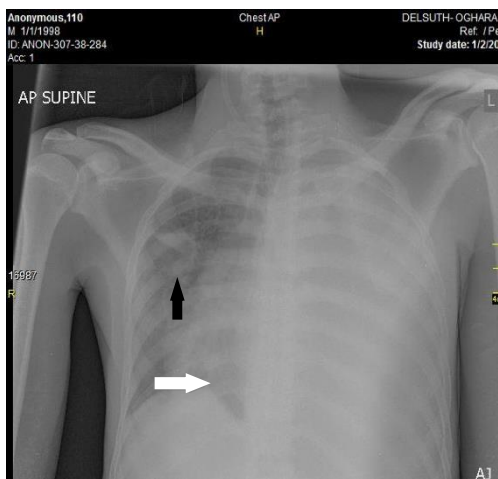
Posteroanterior chest radiograph of a 22-year-old male HIV sero-positive PTB patient showing complete homogenous opacification of the left hemithorax consistent with massive left pleural effusion. Contralateral shift of the mediastinum is noted. Inhomogeneous opacities are also seen in the right mid and upper lung zones. There is tenting of the right hemidiaphragmatic outline caused by fibrotic strands.
